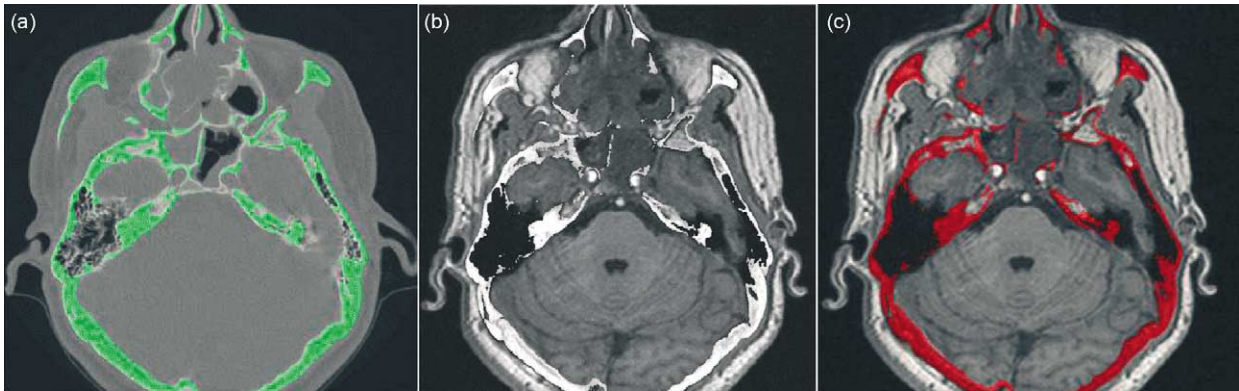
CT image with segmented bone colored in green. b) Fused CT-MR dataset, where the segmented bone from the CT has been overlaid after adjustment of the intensity values on the MR. c) Segmented bone from CT overlaid in red color on the MR image.
